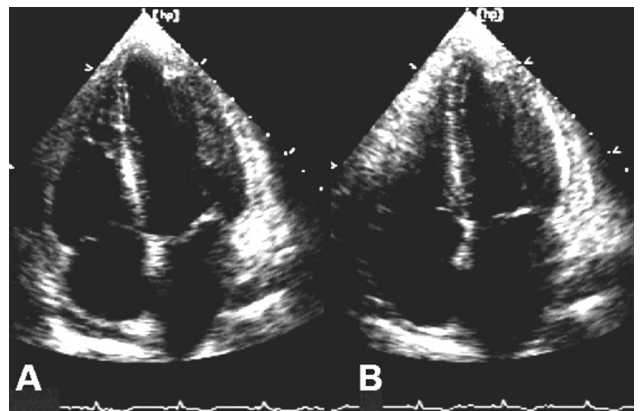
Apical 4-chamber view shows a normal ejection fraction on day 14 after surgery. A, Diastole. B, Systole.
